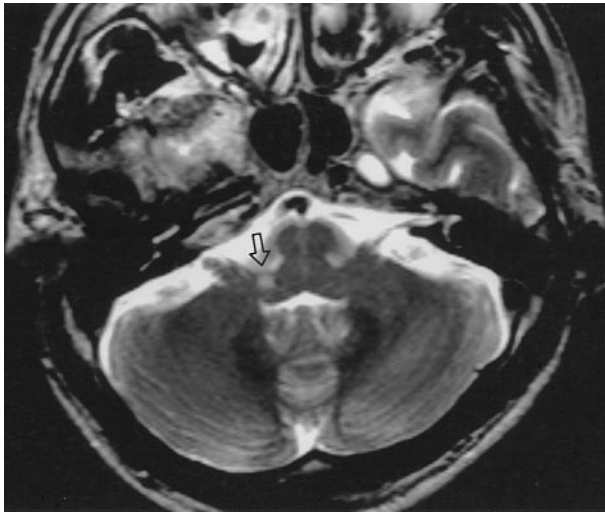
Patient 26. Top, T2-weighted MRI shows an infarct in the left middle medulla. Bottom, Angiogram shows nonvisualization of the left VA. Thyrocervical trunk (arrow) is shown with prominent collaterals (right panel). A part of the upper cervical portion of the VA (arrowhead) was faintly visualized through collaterals from the deep cervical branches (arrow), but the distal part of the VA was not visualized, suggesting occlusion (left panel). This patient had a bilateral distal internal carotid artery occlusion with rete mirabile consistent with moyamoya disease.
